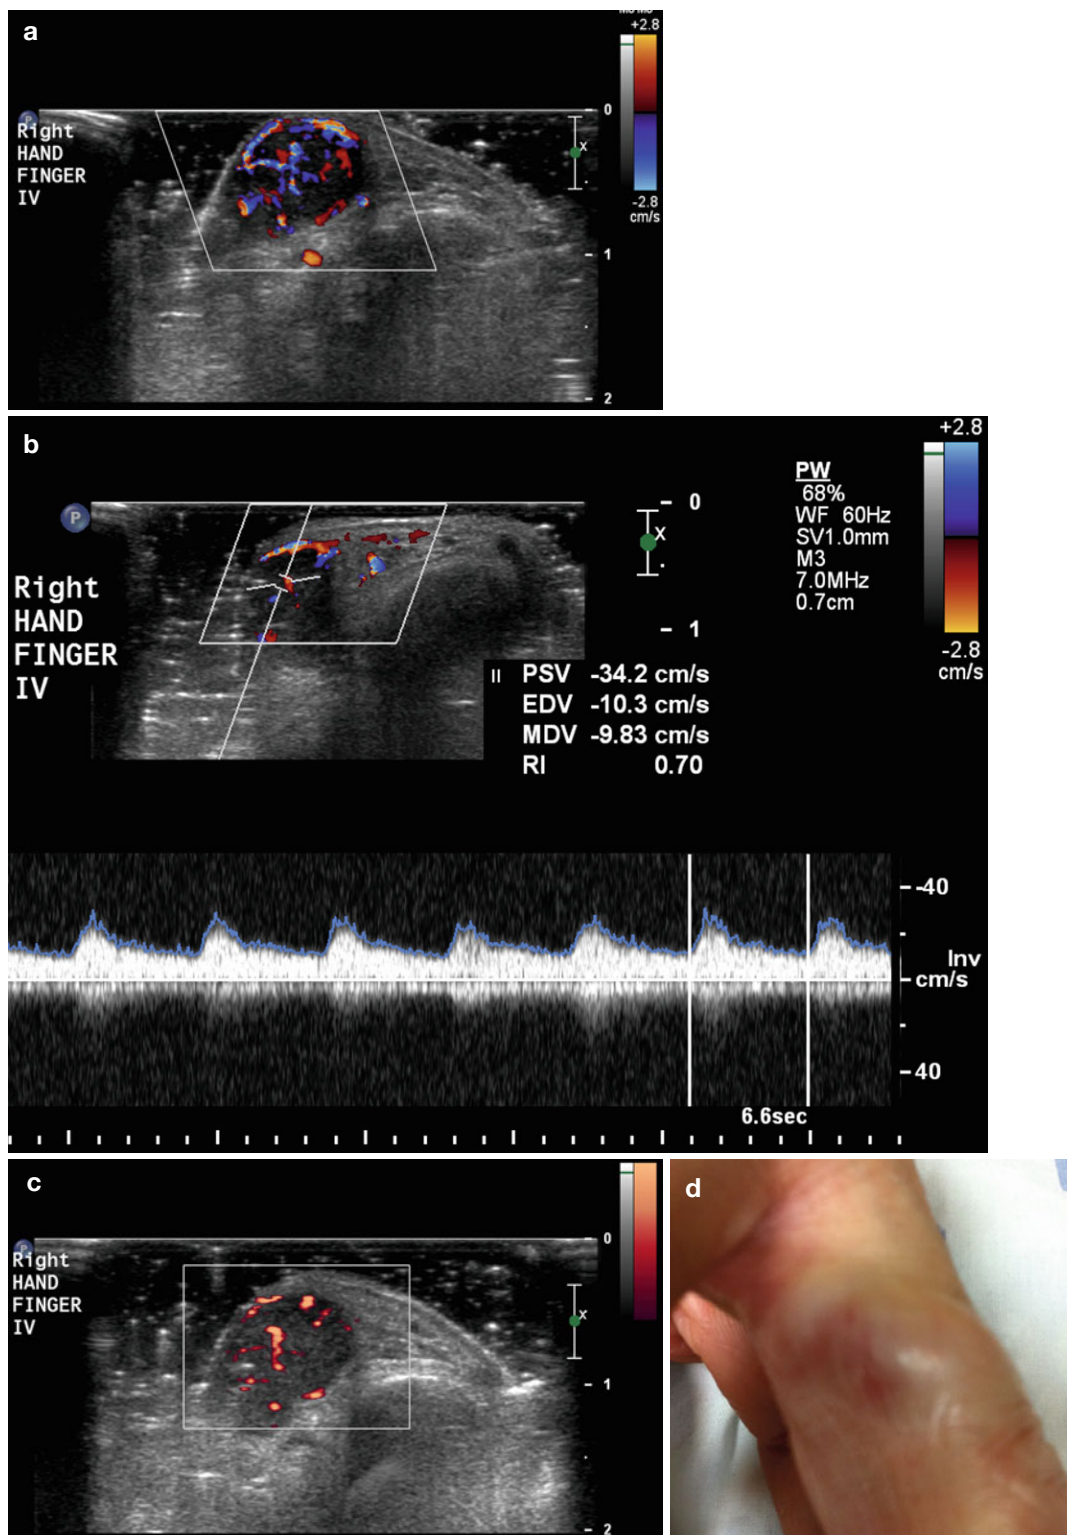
Flow information provided by Doppler sonography. (a) Color Doppler flow. A rich vascularized lesion at the base of the right fourth hand finger, compatible with a vascular malformation is shown. Flowing blood is displayed in a color map, superimposed on the gray-scale image in real time. Flow direction: red toward the transducer and blue away from the transducer (see the color bar shown on the right side of the image), and relative velocity information (lighter hues corresponding to higher velocities) are provided. (b) Doppler frequency spectrum. Changes in flow velocity and flow direction are shown by
